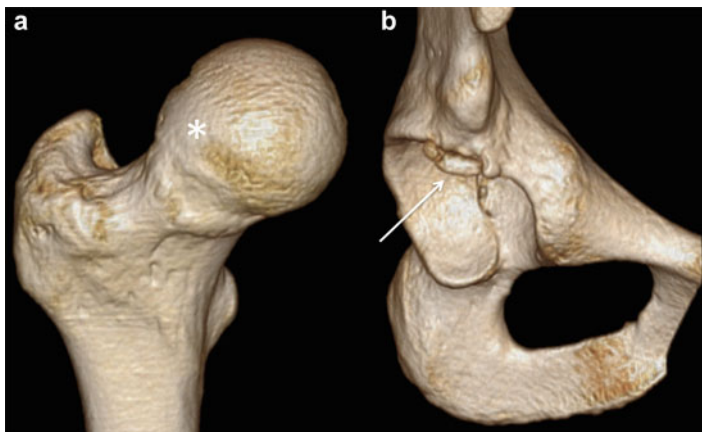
(a) 3D CT reconstruction of the proximal femur showing anterosuperior “cam-type deformity” (*) with reduced femoral head–neck offset. (b) 3D CT reconstruction of the corresponding acetabulum demonstrating focal retroversion and overcoverage secondary to an acetabular rim fracture (*arrow*)
